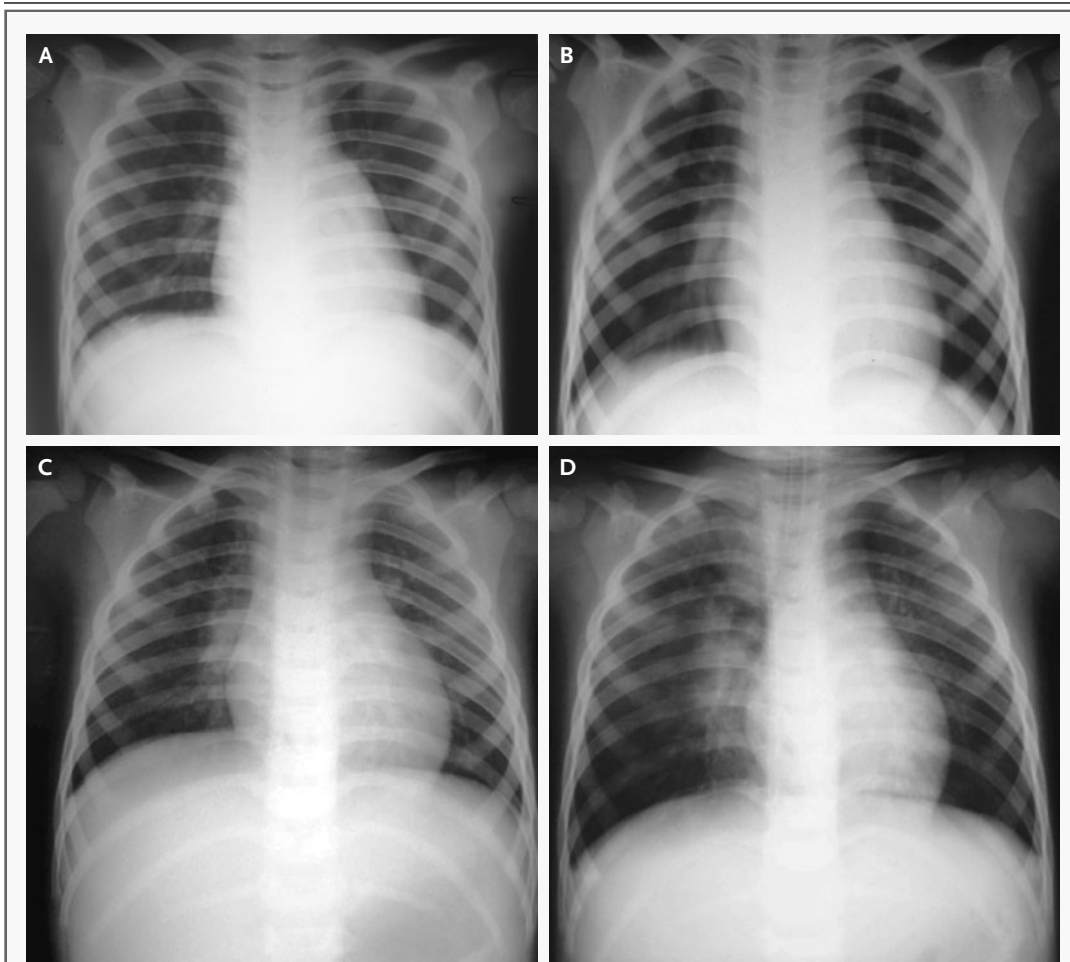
Chest Radiographs from the Two Siblings.
